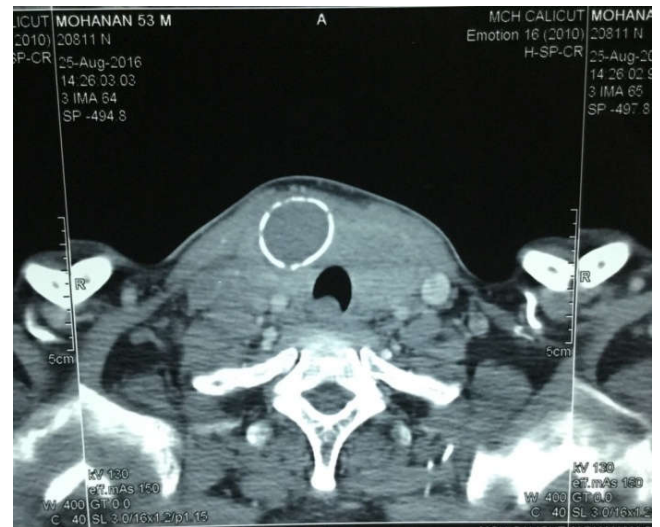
Contrast enhanced computed tomography of neck showed enlarged thyroid gland with multiple ill defined heterogeneously enhancing lesions.
